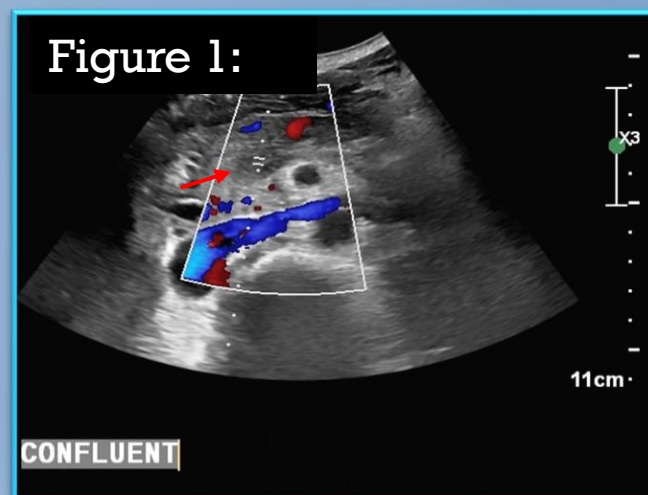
Power doppler image demonstrates no pulse wave and color doppler in portal confluence (arrow).
